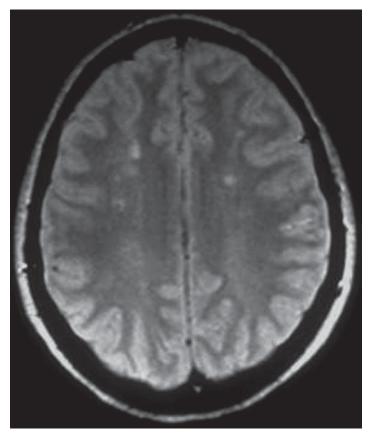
White matter hyperintensity lesions (WMHL) MRI scan.
